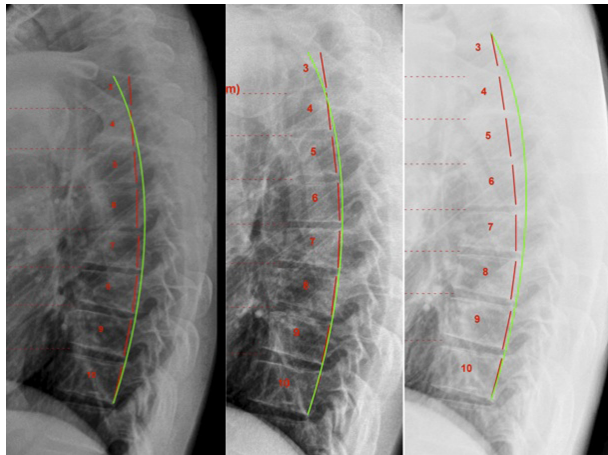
Lateral thoracic radiographs
